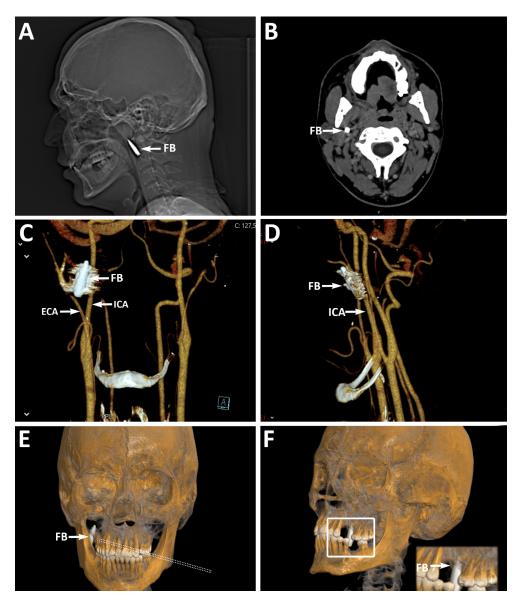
(A) The head CT scout view (topogram) showing the location of the foreign body (FB). (B) Axial view of CT scan of the cranial base showing the position of the foreign body (arrow). (C) Anteroposterior and (D) lateral view of the 3D reconstruction of a CT angiography image showing the position of the foreign body and its relation to the right internal carotid artery (ICA) and external carotid artery (ECA). Due to the metal composition of the foreign body, the artifact surrounding the foreign body is visible. The (E) axial and (F) sagittal view of 3D skull reconstruction showing the position of the bullet (arrows) and an assumed bullet trajectory (dotted lines) (E). FB – foreign body, ECA – external carotid artery, ICA – internal carotid artery.
